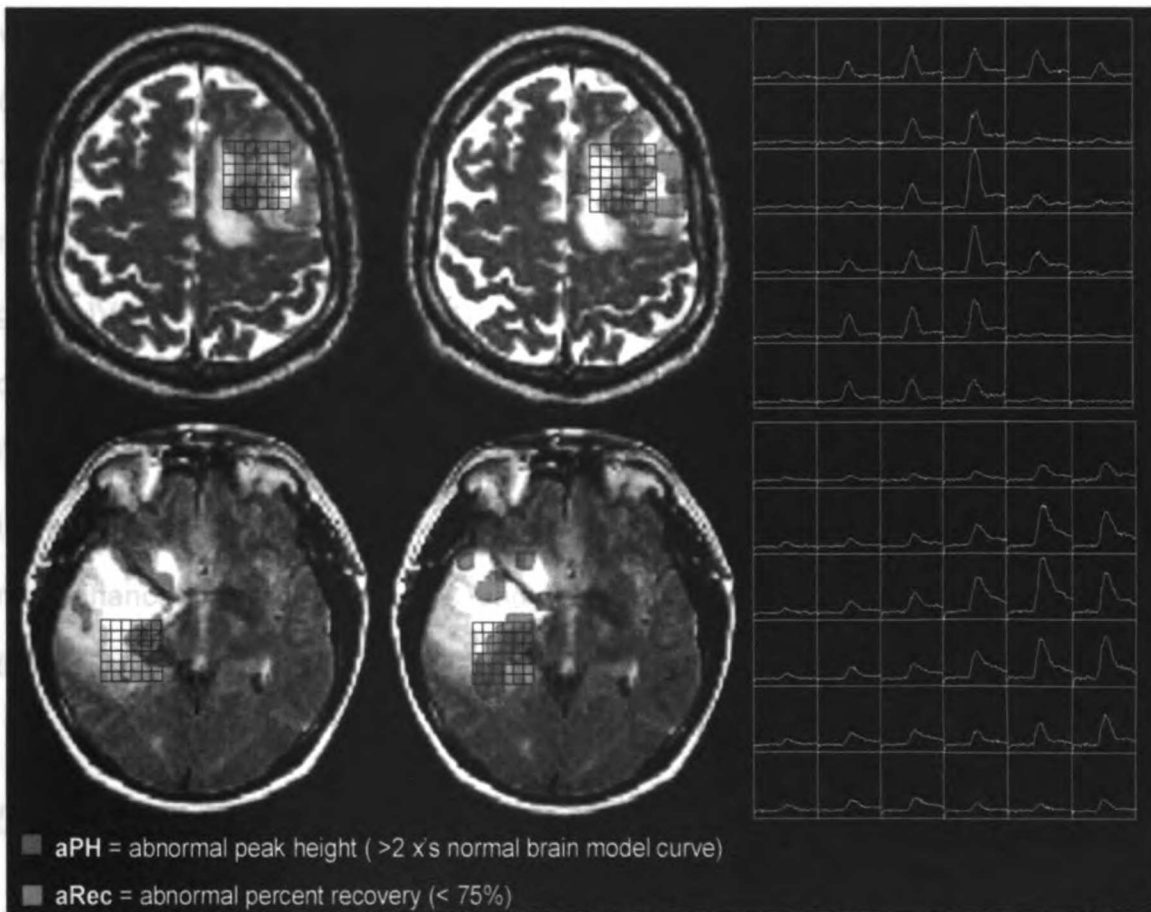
Example of abnormal peak height (aPH; left) and abnormal recovery (aRec; center) maps for grade IV (top) and grade III (bottom) gliomas overlaid on a T2-weighted image (top – FSE, bottom – FLAIR) and the $\Delta R2^*$ curves from which they were derived (right).
